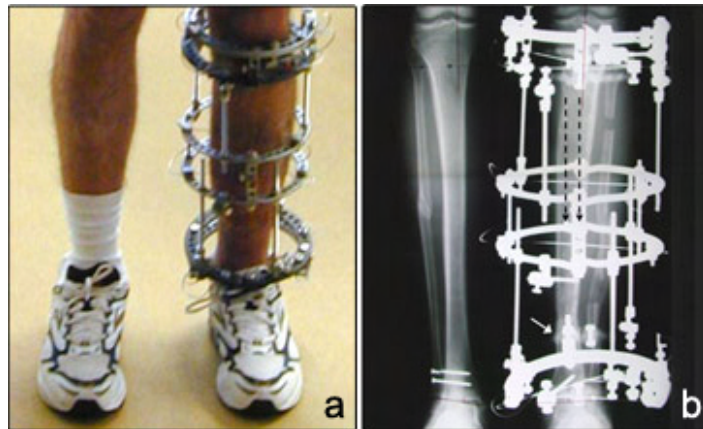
a) An Ilizarov fixator, commonly used in the stabilization of bone fracture b) The corresponding X-ray image. Image from [web] used by permission.
